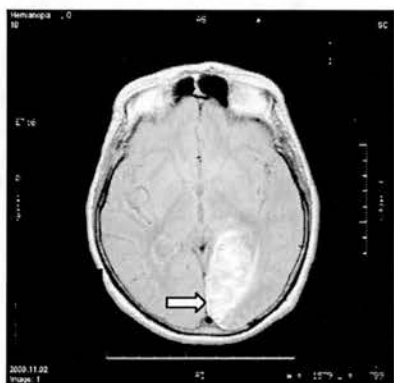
Ischaemia on MRI – Proton density sequence, hyperintensity in left occipital region (arrow) associated with swelling causing the occipital pole of the left lateral ventricle to be pushed forward
